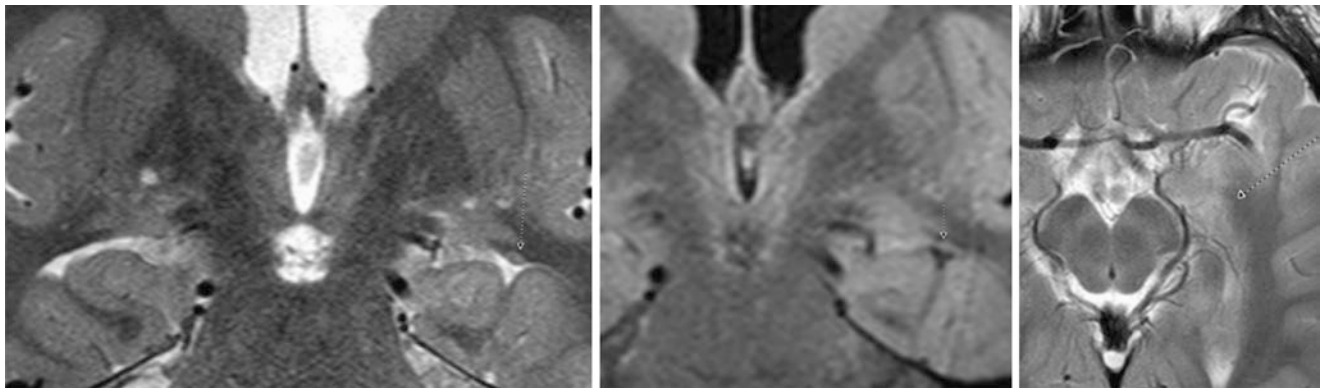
The patient was a 7 year old with developmental delay. On a negative 3 T MRI, a coronal T2WI (*left*) depicts the left caudate tail. Localizer arrows (*tiny dotted arrows*) demonstrate how difficult it is to
